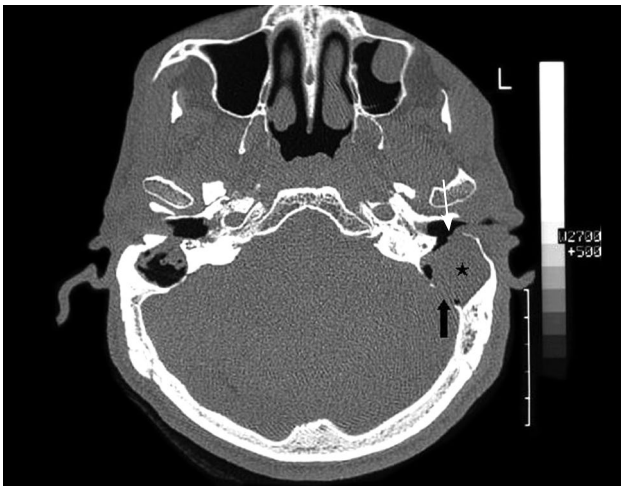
Axial temporal bone computed tomography shows temporal bone fungus ball (asterisk), erosion of inner mastoid cortex (arrow) and destruction of the medial portion of posterior ear canal wall (white arrow).
